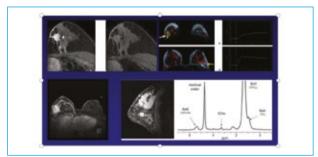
MRI examination pictures of 1 patient.
